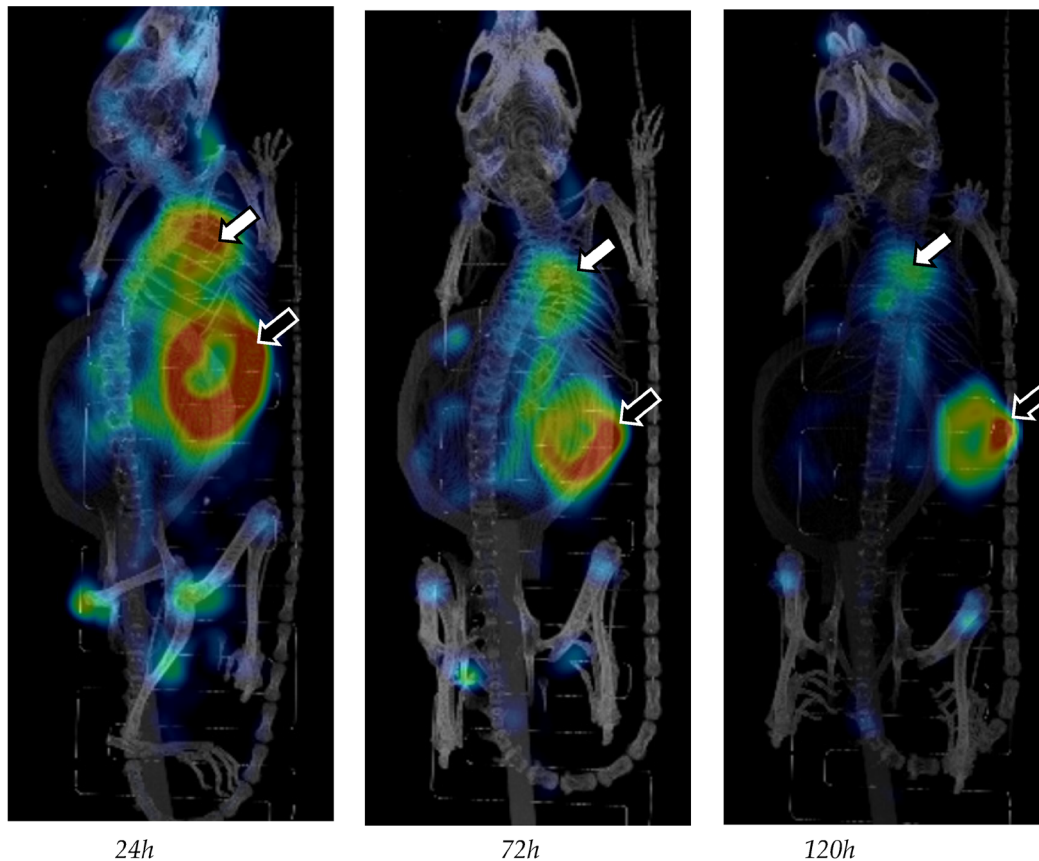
Reconstructed 3D body scans were visualized using maximum intensity projection at 24, 72 and 120 h, and the SPECT scale was adjusted by cutting 10% of the lower signal intensity to make the high-intensity regions readily visible. The white arrow points to the heart and the black arrow points to the infected implant. An increased signal is seen at the hips and knees probably due to detached ¹¹¹In.
